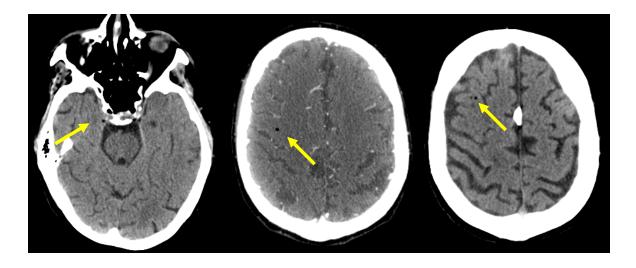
Head CT scan showing air Embolism. Note the discrete air embolism patterns in the cavernous sinus, corona radiata and frontal lobe.
